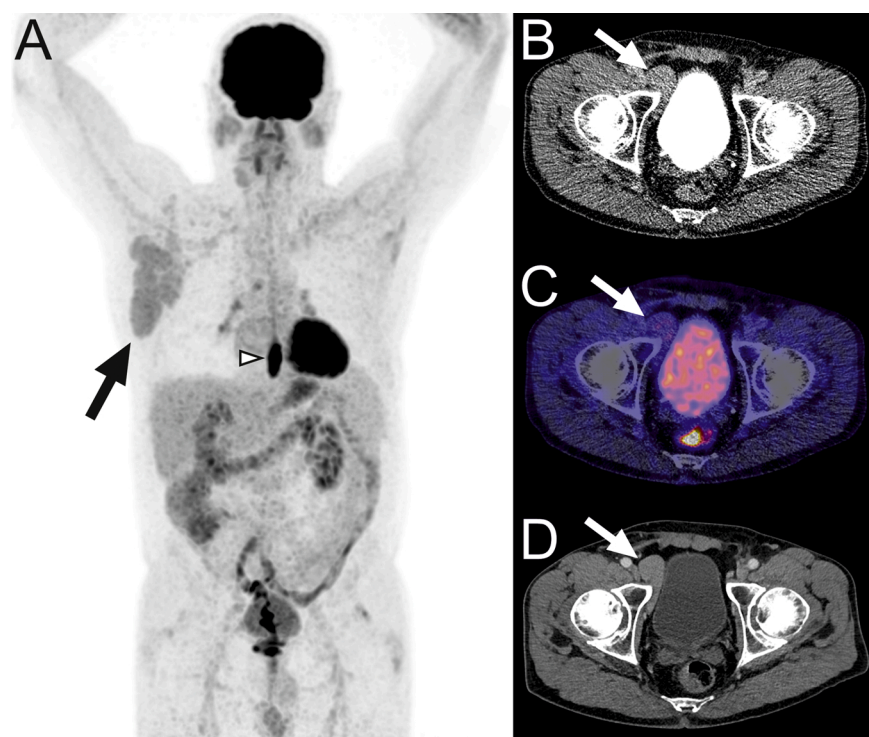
A 69-year-old man with a history of chronic lymphocytic leukemia and palpable lymphomas in the right axilla. Low-dose FDG-PET/CT and concomitant full-dose contrast-enhanced CT were performed for staging purposes. Coronal maximum intensity projection FDG-PET (A), axial low-dose CT (B), axial fused FDG-PET/CT (C), and axial full-dose contrast-enhanced CT (E) are demonstrated. FDG-PET showed right axillary lymphomas with low FDG-avidity (A, arrow) and focal high FDG uptake in the distal esophagus (A, arrowhead), the latter suspicious for esophageal cancer. Although right para-iliac non-FDG-avid lymphomas were also visible (B-D, arrows), they were not described in the original report. This perceptual error was corrected with an addendum 22 days after authorization of the original report.
